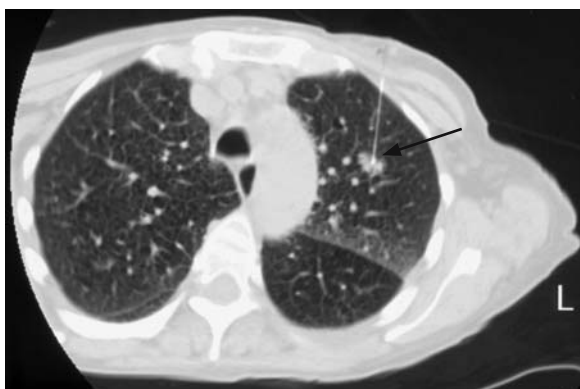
CT guided 22-gauge fine needle biopsy of a primary non-small cell carcinoma of the left upper lobe
